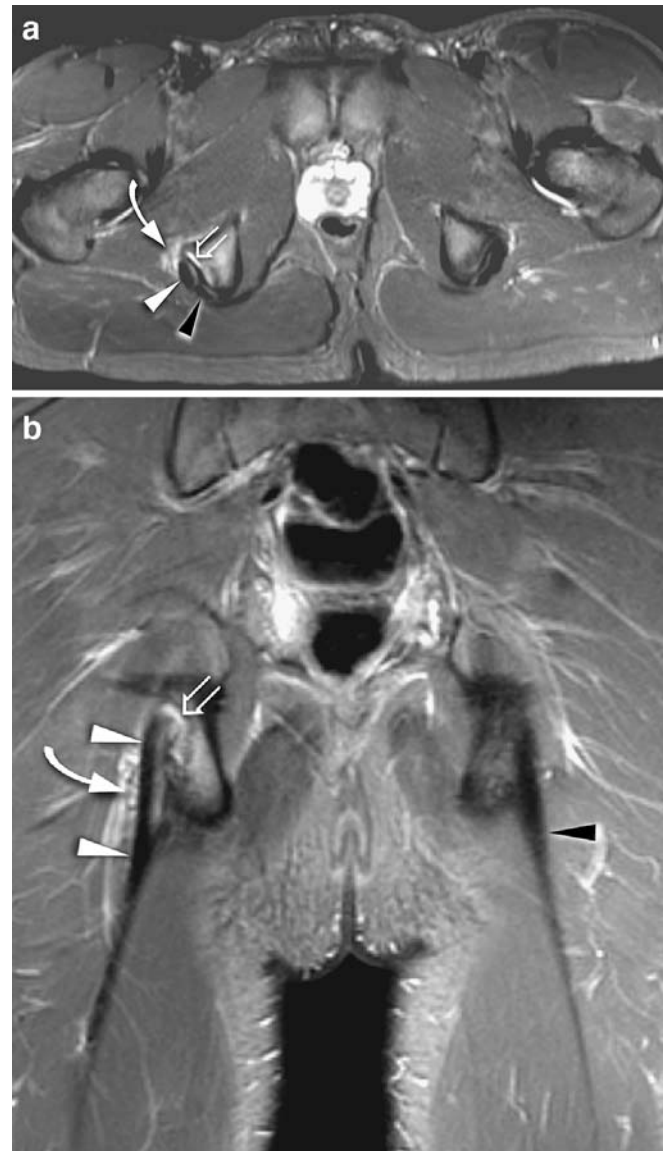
MR imaging findings of hamstring avulsion injury with tendinosis of the semimembranous tendon. a Axial and b coronal fat-suppressed proton density-weighted turbo spin echo images. At the insertion of the semimembranous tendon anterolateral (white arrowhead) increased signal within the tendon, edema-like abnormalities of bone marrow (open arrow) and edema of the surrounding soft tissue (curved arrow) are visible. The conjoint tendon of the biceps femoris and the semitendinosus muscles (black arrowhead) is normal
